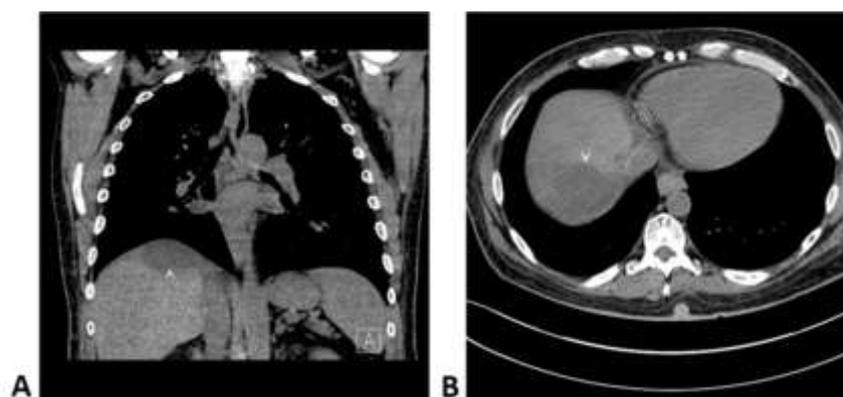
A and B. Coronal and axial non-contrast CT images demonstrate a heterogeneous complex subdiaphragmatic fluid collection (*arrowheads*) thought to be a hematoma.
